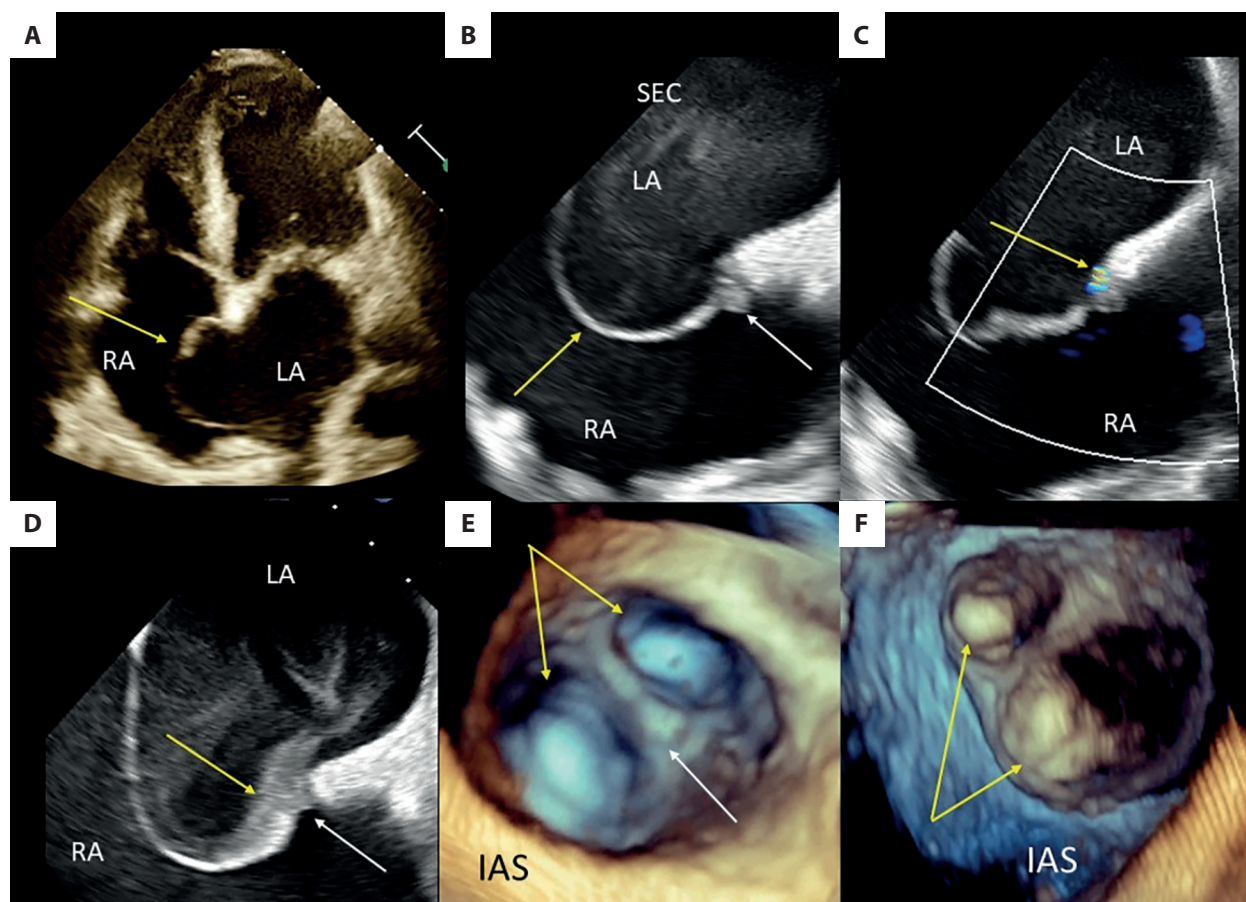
A. Atrial enlargement and bulging of the interatrial septum toward the right atrium (arrow); transthoracic echocardiography; a 4-chamber view. B. Large atrial septal aneurysm (yellow arrow) and small thrombus in the PFO channel on border of aneurysm (white arrow). C. Small point left-to-right shunt through PFO (arrow); 2-dimensional transesophageal echocardiography, color Doppler. D. Follow-up: more dense blood in aneurysm cavity (yellow arrow) and smaller PFO thrombus (white arrow); 2-dimensional transesophageal echocardiography. E. Unusual morphology of atrial septal aneurysm: two recesses separated by a septum (arrows), view from the left atrium. F. Atrial septal aneurysm — view from right atrium; 3-dimensional transesophageal echocardiography
